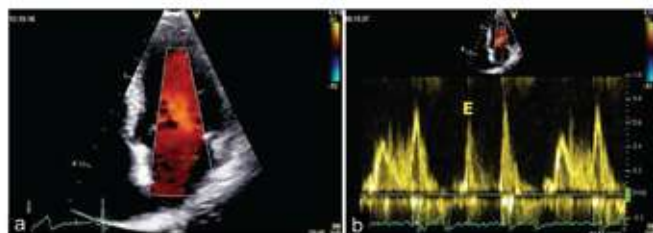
(a) Color flow across the mitral valve in the color left atrium - left ventricle view; (b) mitral inflow pulsed-wave spectral Doppler
